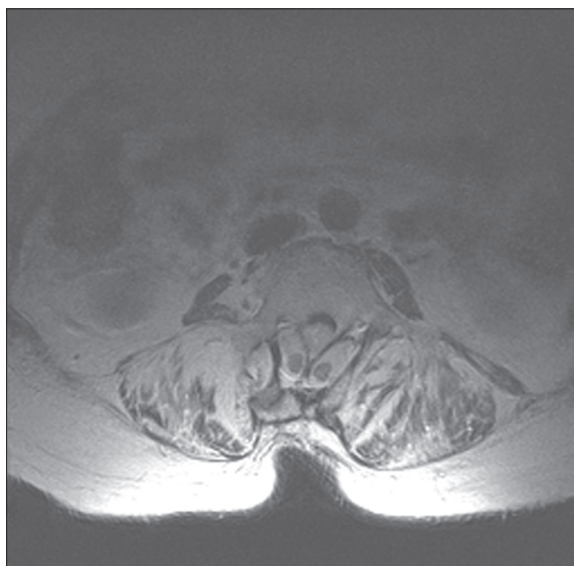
T2-weighted image, axial plane, level L3: two hemicords, each contained in a separate dural tube and separated by an osseocartilaginous septum.
